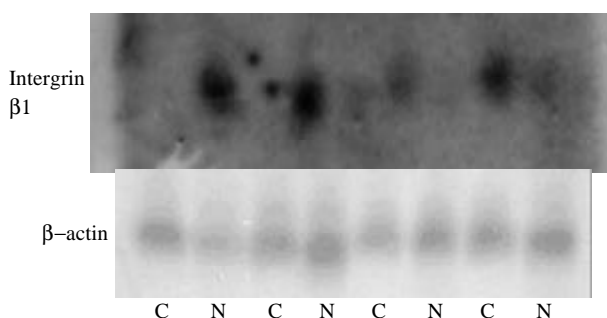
Nothern blot analysis of Intergrin beta1, which differentially express in human hepatocellular carcinoma and adjacent normal liver tissues, to confirm the Atlas human cancer cDNA expression array. Four paired cases are used to determine these genes expression patterns. Twenty μ g RNA is analyzed on a 1.2% denaturing agrose gel and tansfer onto a nylon membrane. 32 P-labeled cDNA probes for these genes are hybridized to the RNA-bloted membranes. After stringent washes, membranes are exposed to X-ray film overnight at -70°C . The same membranes are rehybridized with human β -actin for an RNA loading control. (C, human hepatocellular carcinoma tissue; N, adjacent noamal liver tissue)
